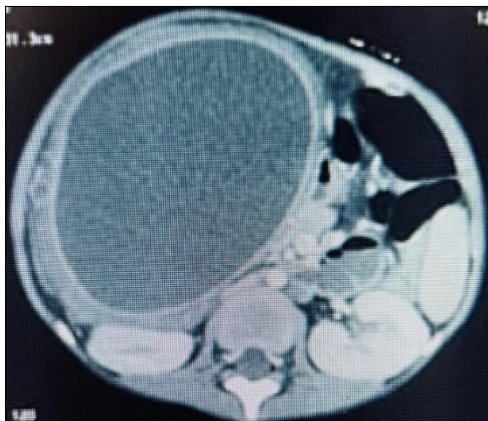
CT Scan: Voluminous intra-peritoneal cystic lesion at the hepatopancreatic junction
